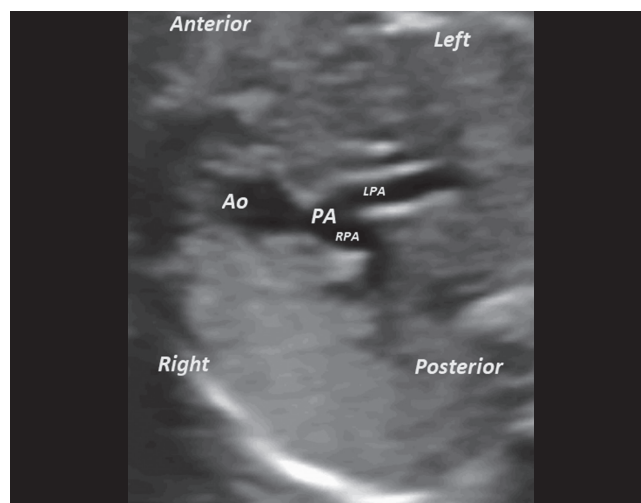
The fetal cardiac ultrasound in the short-axis view of the great arteries shows dextro (D) malposition or right and anterior positioning of the Ao, the PA, the RPA, and the LPA.
